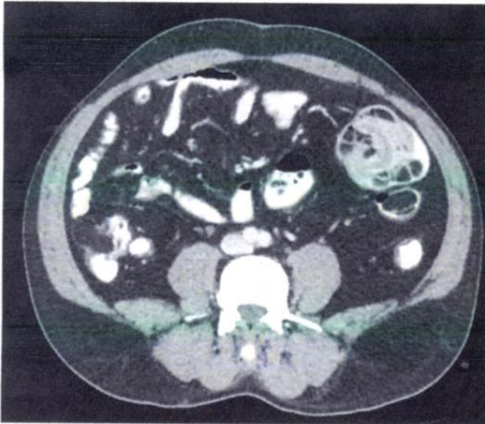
Abdominal computed tomography scan showing intussusception.
